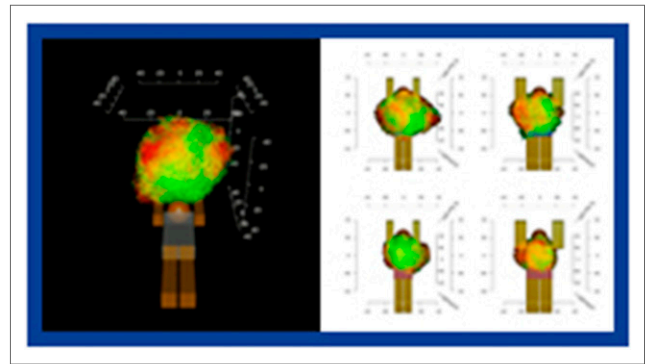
Sex-specific effects of patient positioning on myocardial perfusion imaging with a cadmium-zinc-telluride SPECT camera. Color spots represent areas under the curve (AUCs) for diagnostic performance based on location, sex, and body mass index (BMI) (AUCs: green = 0.8–1.0; yellow = 0.7–0.8; orange = 0.6–0.7; red = 0.5–0.6). Left: all patients. Right block: top, men; bottom, women; left, BMI < 27; right, BMI ≥ 27. Some perfusion defects may be attributed to positioning, which may affect diagnostic performance in multipinhole CZT scanners.
